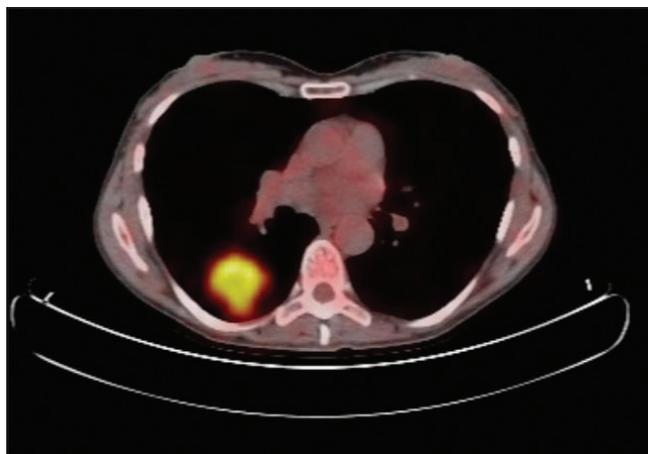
PET/CT demonstrating pathological FDG uptake within the right lower lobe
